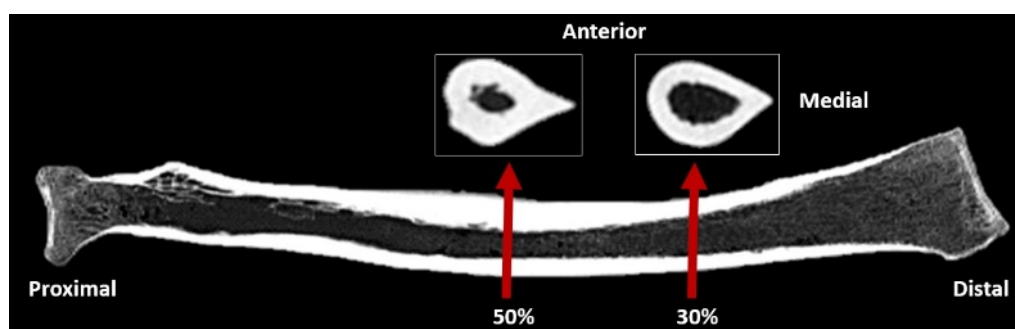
Representative whole-bone CT scan of the radius with VOIs defined at 30% and 50% of total length (measured from the distal articular surface).
